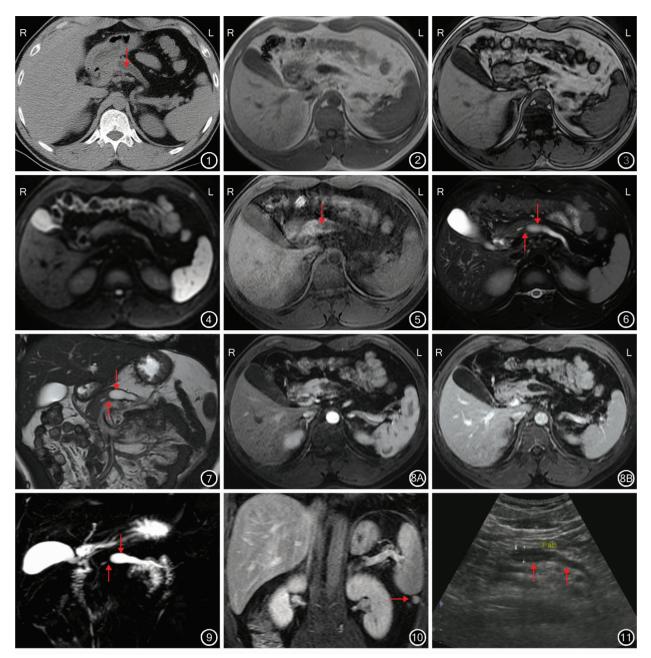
患者人院时 CT 检查示胰体、尾部实质萎缩,密度均匀,主胰管扩张(↓) 图2 患者人院时 MRI 检查同相位示胰腺实质信号均匀 图3 患者人院时 MRI 检查反相位示胰腺实质信号衰减 图4 患者人院时 MRI 检查 DWI 示胰腺实质信号均匀,无弥散 图5 患者人院时 MRI 检查 T1WI 示胰体部实质萎缩,主胰管明显扩张(↓) 图6 患者人院时 MRI 检查 T2WI 示胰腺长度 无缩短,边缘光滑,实质信号均匀,胰体、尾部主胰管明显扩张(↓),颈部主胰管变窄(↑) 图7 患者人院时 MRI 检查冠状位 Fiesta 示胰体、尾部主胰管明显扩张(↓),内壁光整,颈部主胰管变窄(↑) 图8 患者人院时 MRI LAVA 增强扫描示胰腺实质均匀强化,扩张的胰管内无异常强化灶 LAVA:肝脏容积加速采集 8A:动脉早期;8B:门静脉期 图9 患者人院时 MRCP 检查示胰体、尾部主胰管明显扩张(↓),颈部主胰管变窄(↑),肝内、外胆管、胆囊未见扩张 图10 患者人院时 MRI LAVA 增强扫描平衡期示脾脏下缘一圆形软组织信号影(→),信号强度与脾脏一致 图11 2014年11月,患者超声检查示胰头部体积稍增大,内部回声分布均匀,胰体、尾部缩小,主胰管扩张(↑)
